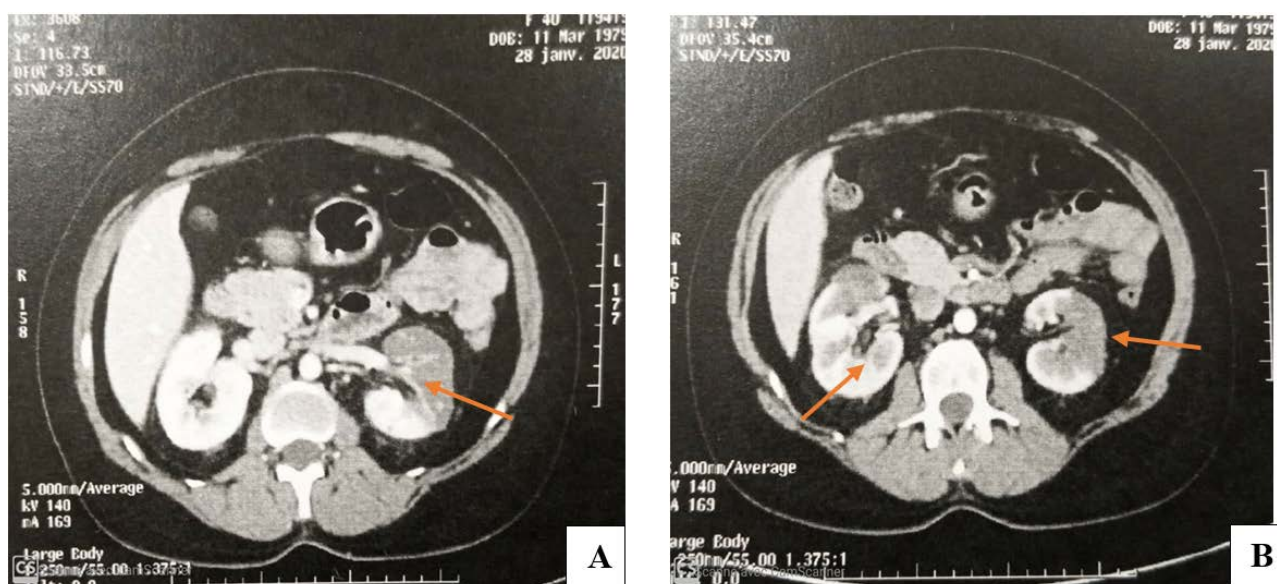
(A) and (B) Axial CT scans with contrast injection at the arterial phase showing bilateral renal corticomedullary triangular hypodense areas that do not enhance after contrast injection, corresponding to foci of renal infarction.
